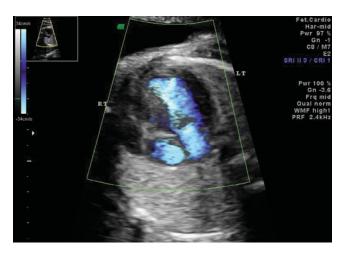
Power Doppler showing lack of filling of the hypoplastic right ventricle.
